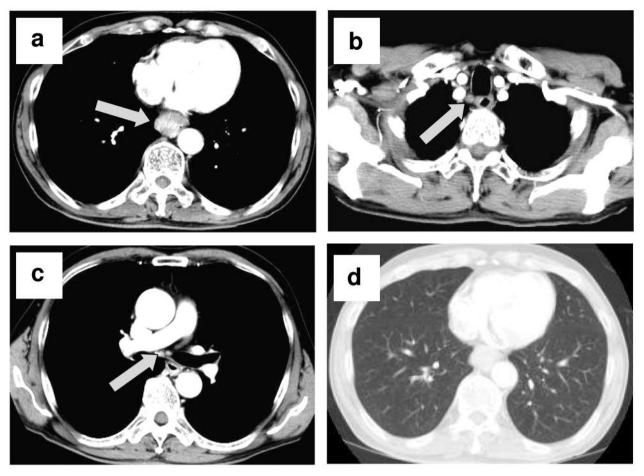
Chest computed tomography (CT): a.b.c. The chest CT showing irregular wall thickening in the lower esophagus (arrow, a) and enlarged lymph nodes at the right recurrent nerve (arrow, b) and the subcarina (arrow, c). d. No primary or metastatic tumor evident in the lung fields.
